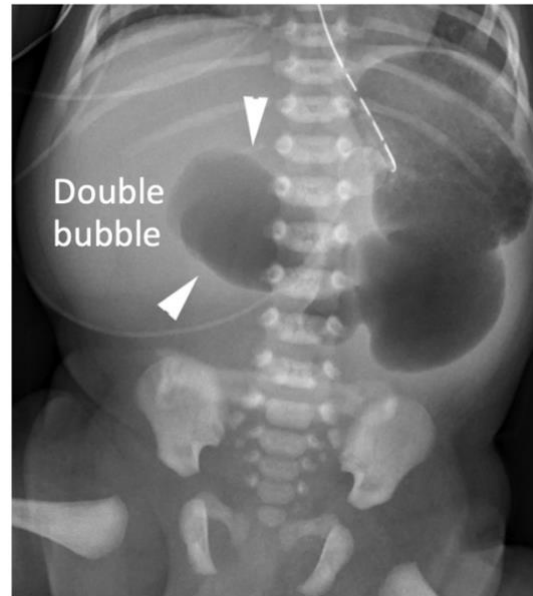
Abdominal radiograph showing "double bubble" sign in patient with duodenal atresia.³
